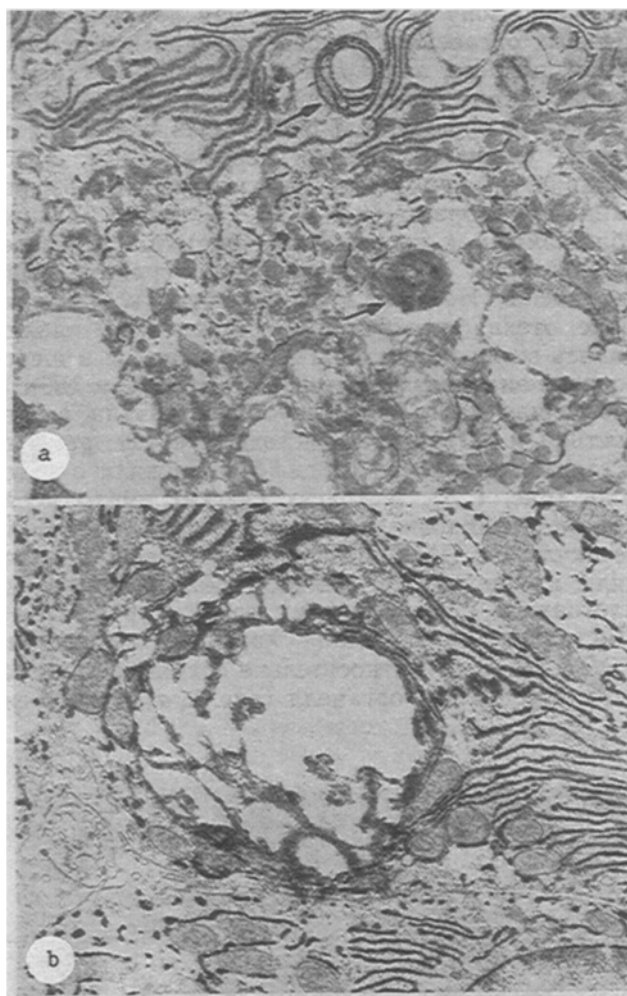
Liver damage 24 h after incision made with ultrasonic destructor. Active zone. a) Progressive fatty degeneration and formation of autophagosomes (arrows). 11,100 $\times$ , b) Large lipid drop containing fragments of cytosol and organelles in its substance. 11,100 $\times$ .
